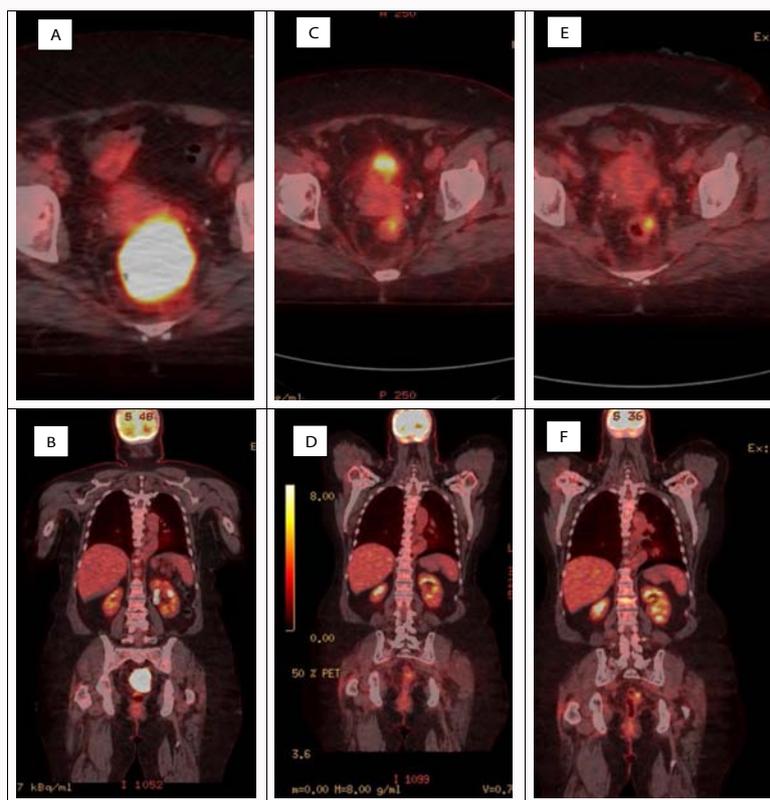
FDG PET-CT: Upper panel shows axial images. Lower panel corresponding coronal images. A/B: Baseline; C/D: 3 months post treatment; E/F: 5 months post treatment.
